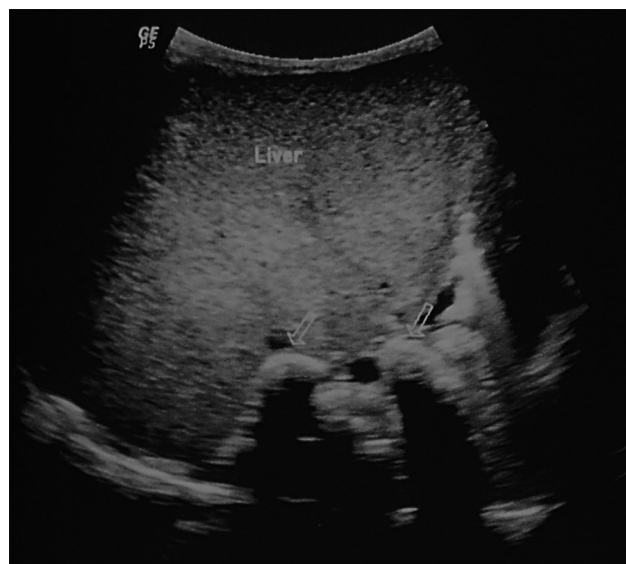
Ultrasonographic image showing hepatomegaly. Also note the enlarged calcified adrenal glands casting distal acoustic shadowing (arrows).
